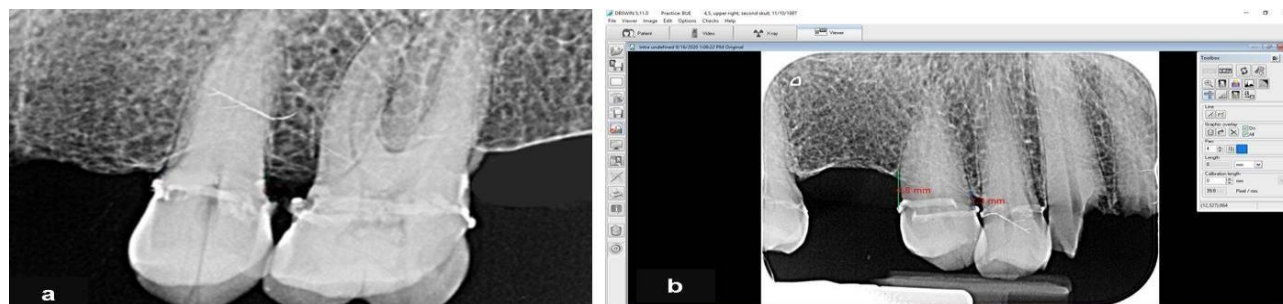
Intraoral digital radiograph a: furcation involvement and horizontal bone loss distal to the upper left first molar, b: alveolar bone loss measurements on digital radiography software.
